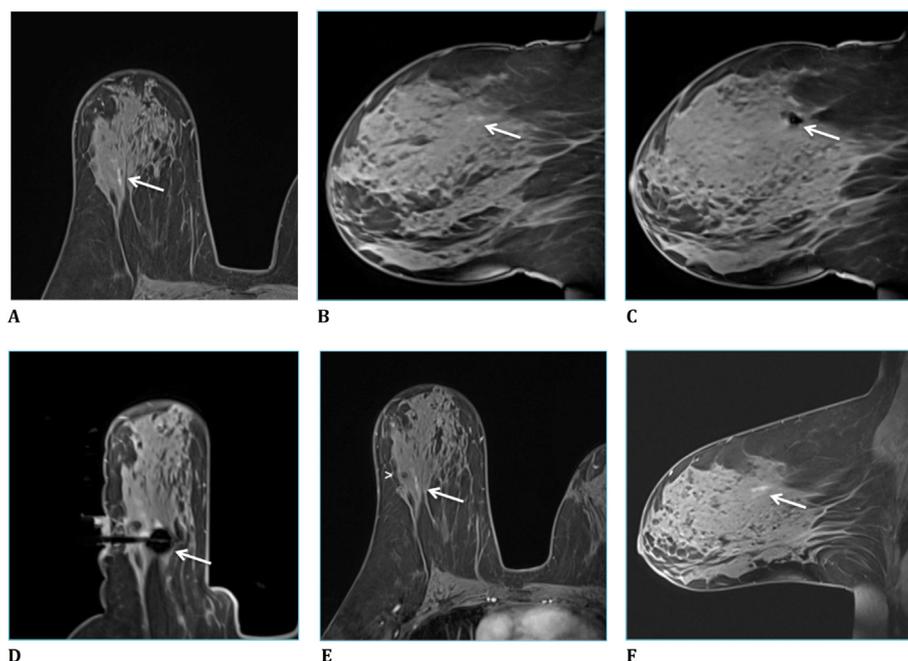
53 year-old female with BRCA-1 mutation and history of prior contralateral breast cancer undergoing high risk screening MRI. Initial biopsy for linear nonmass enhancement (NME) revealed dense stroma and rare stromal microcalcifications. Follow up MRI at 7 months showed the tissue marker was lateral to the target. Re-sampling demonstrated ADH, which was upgraded to DCIS at surgical excision.
